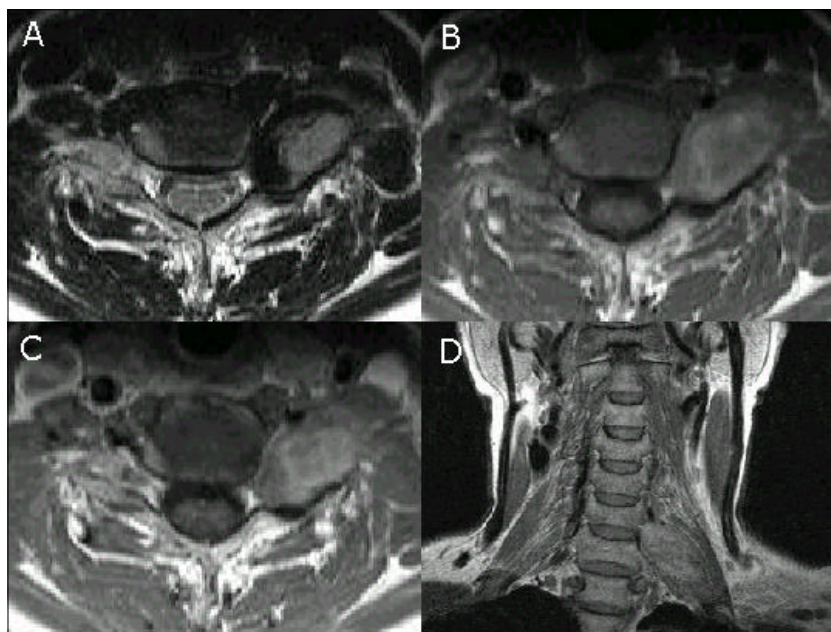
Axial T2-weighted, T1-weighted, T1-contrast enhanced MRI scans (A, B, C & D, respectively) show a well-defined ovoid mass that is extended from the intervertebral foramen to the scalene muscles.
